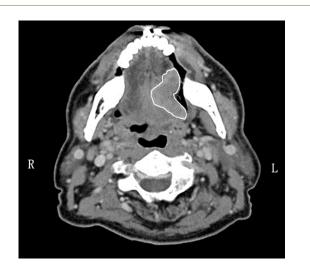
CT imaging of pre-therapy. Tumour was located in left side edge of tongue, that diameter was 41 mm.
